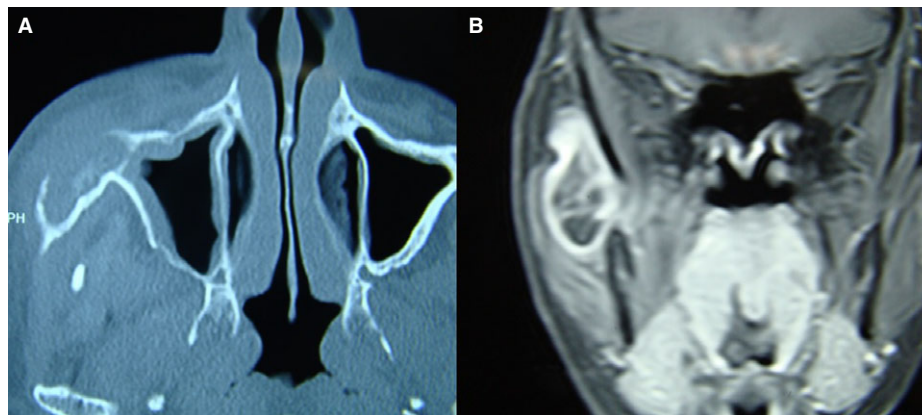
Axial and coronal CT images.
